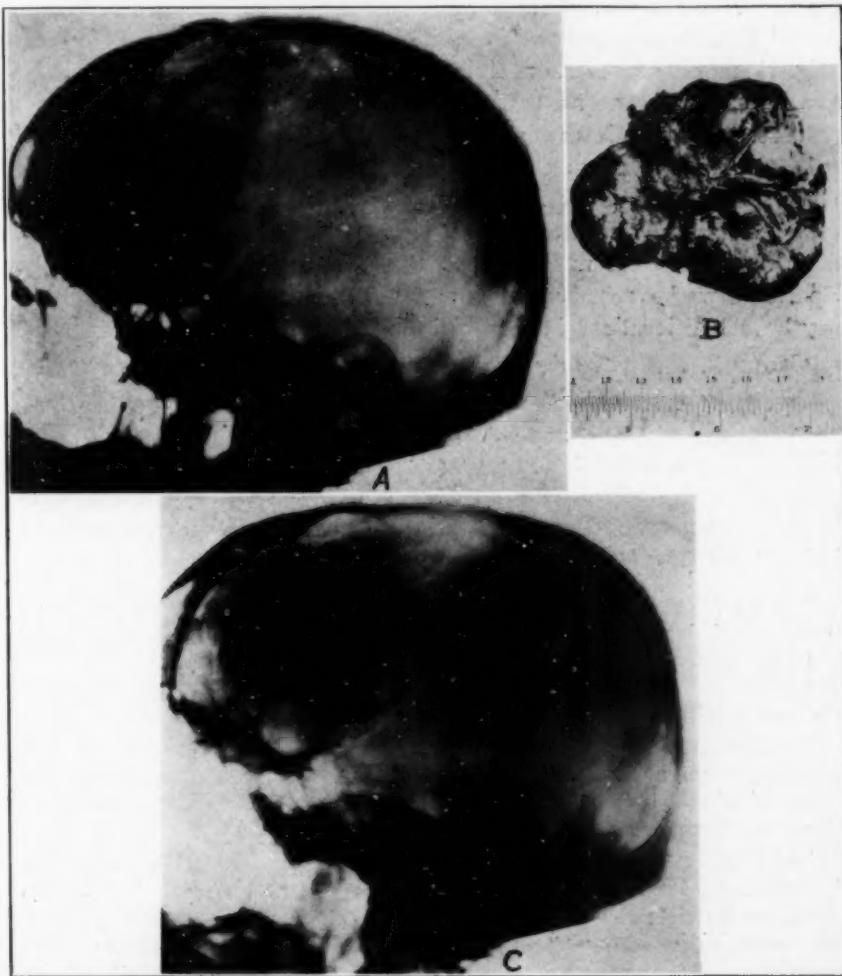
Endothelioma of left frontal lobe. Roentgenogram showing enlargement of left anterior temporal diploic veins.
